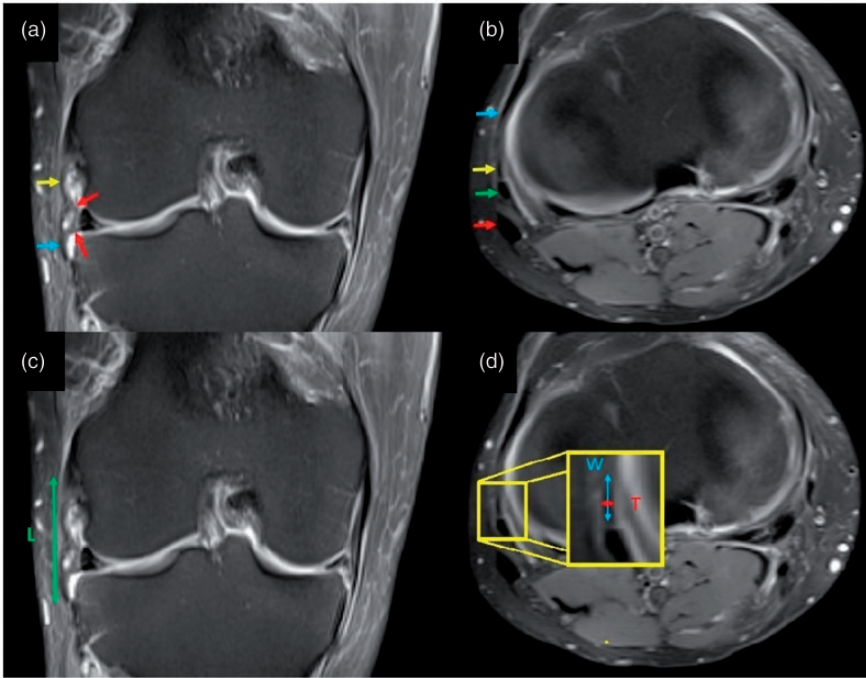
Representative fat-saturated proton density-weighted coronal (left) and axial (right) magnetic resonance images without ligament injury. (a) In the coronal plane, the femoral part (yellow arrow), the meniscal part (red arrows), and the tibial part (blue arrow) of the anterolateral ligament is observed. (b) In the axial plane, the iliotibial band (blue arrow), the anterolateral ligament (yellow arrow), the lateral collateral ligament (green arrow), and the biceps femoris tendon (red arrow) are indicated. Measurements of the (c) length and (d) thickness and width of the anterolateral ligament are shown.
